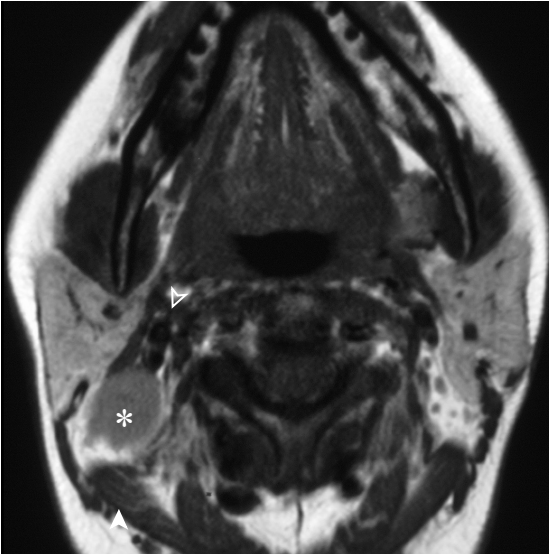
Axial T2 MRI (same patient) shows a necrotic nodal metastasis (*), sandwiched between the carotid bifurcation (Δ), and sternocleidomastoid muscle (▲). FNAC may be needed to differentiate it from an infected / hemorrhagic 2nd BCC.
